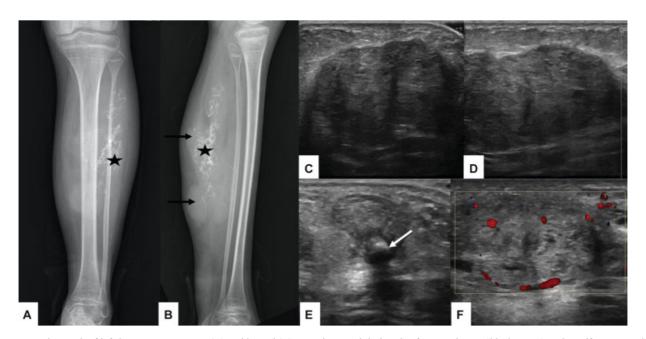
Radiograph of left leg anteroposterior (A) and lateral (B) view showing lobulated soft tissue lesion (black arrow) in the calf region with dense amorphous calcification (asterisk). Thinning and scalloping of fibula without obvious bony destruction is seen. Ultrasound images (C-E) showing lobulated predominantly echogenic lesions with no compressible venous spaces. Presence of calcification (white arrow) with posterior acoustic shadowing seen within the lesion. Color Doppler (F) image showing minimal venous flow.
